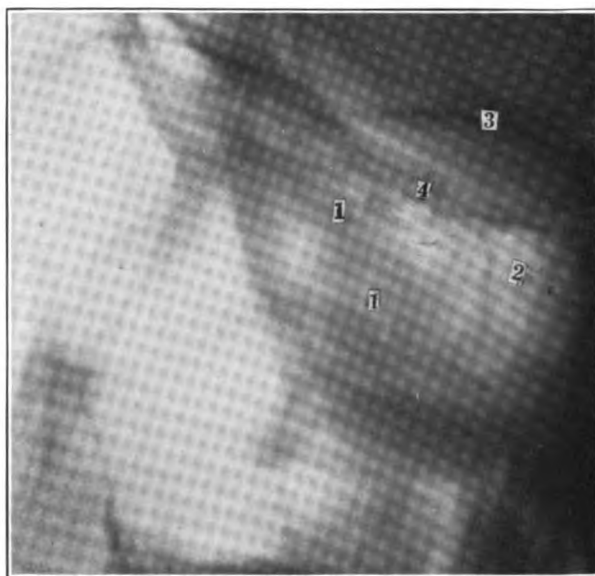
Roentgenogram showing anterior ethmoiditis at 1, 1; 2, normal sphenoid; 3, orbital margin; 4, suture line. Note blurring in diseased areas (left side).
